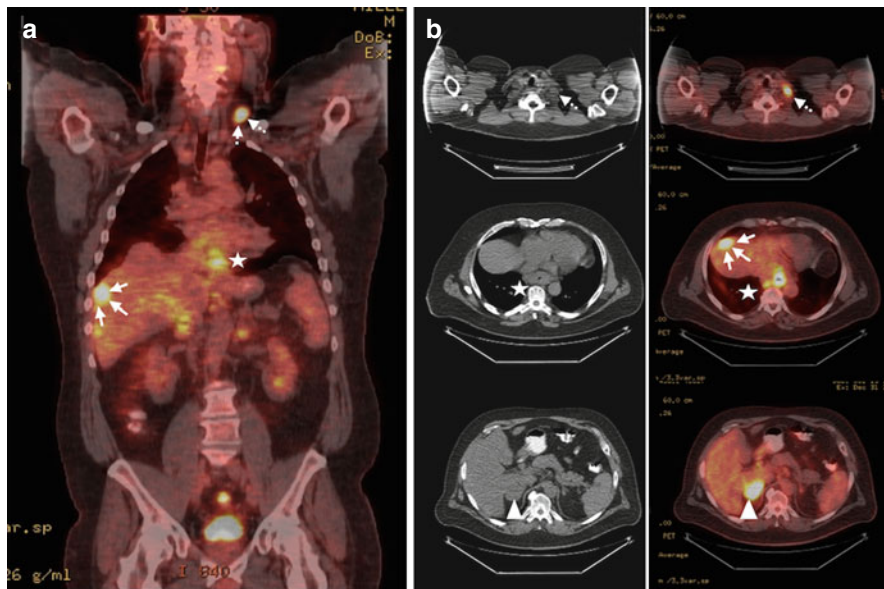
Primary staging with fused PET/CT showing metastatic diseases in distal esophageal cancer. (a) Coronal view with SUV uptake in left cervical lymph node (*dashed arrow*), distal esophagus (*star*), and focal hepatic lesion (*solid arrows*). (b) Corresponding axial view with focal uptake in cervical, esophageal, and hepatic uptake, bottom pictures showing additional right adrenal SUV uptake (*triangle*)
